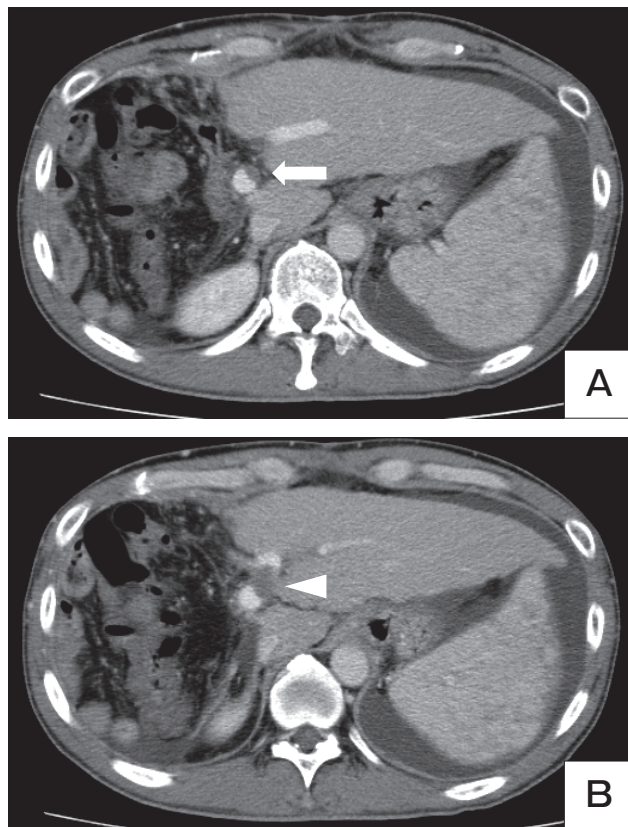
Computed tomography (CT) images before living donor liver transplantation. A, The thrombus was found on the left wall of the main and left portal veins (arrow), with massive ascites and severe splenomegaly; B, The localized thrombus (arrowhead) was detected in the umbilical portion of the portal vein, occluding most of the lumen.
